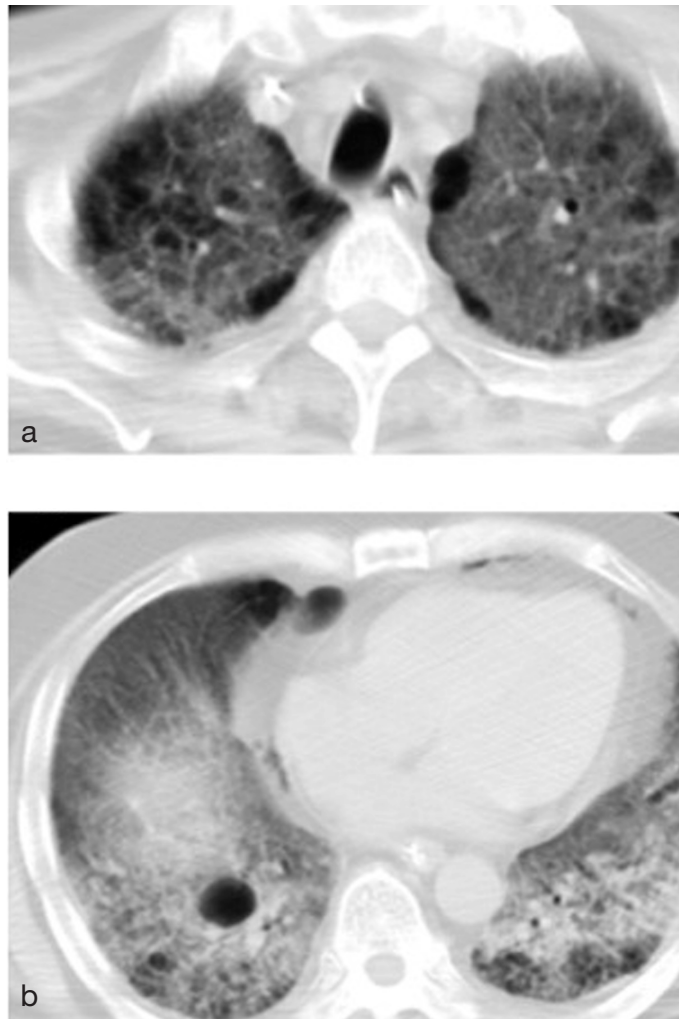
a and b: On chest CT on day 16, the GGO findings were worse than on chest CT on arrival.
